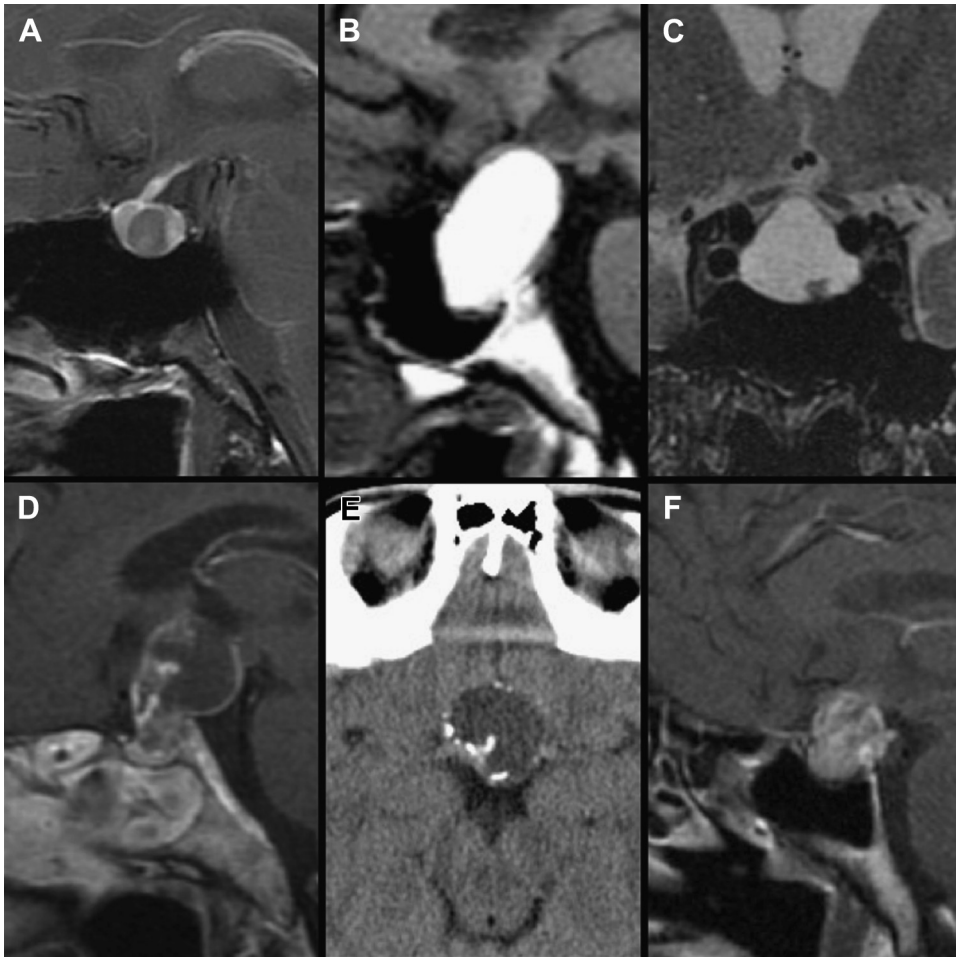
Rathke cleft cysts (A–C) and craniopharyngioma (D–F). (A) Classic Rathke cleft cyst seen as a rounded, non-enhancing sellar mass within the pars intermedia. (B) “Machine oil” cyst with uniform high T1 signal on unenhanced T1-weighted image. (C) Fluid-type Rathke cyst with high T2 signal and eccentric mural nodule. (D) Adamantinomatous craniopharyngioma gadolinium-enhanced MRI and (E) unenhanced CT in the same pediatric patient, showing solid and cystic mass with eccentric mural calcification. (F) Note the more solid appearance of squamous-papillary craniopharyngioma in an adult.
